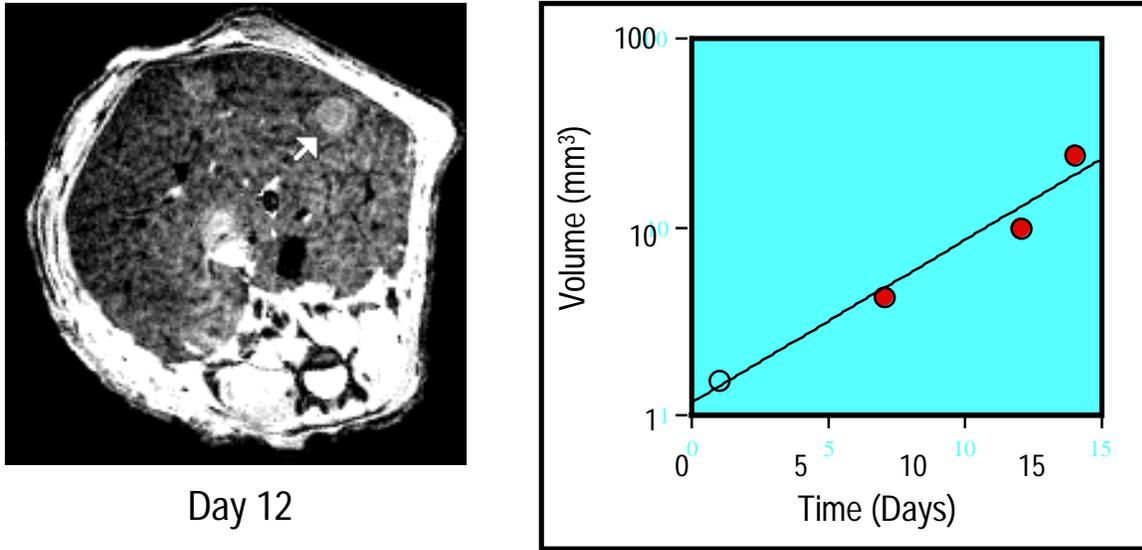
Measuring Rates of Tumor Growth with MRI. Tumor was produced by initiation with vinyl carbamate followed by administration of DCA at 2 g/L for approximately 24 weeks. The tumor was imaged on successive days indicated in the chart. Image provided was on day 12 of the experiment.
